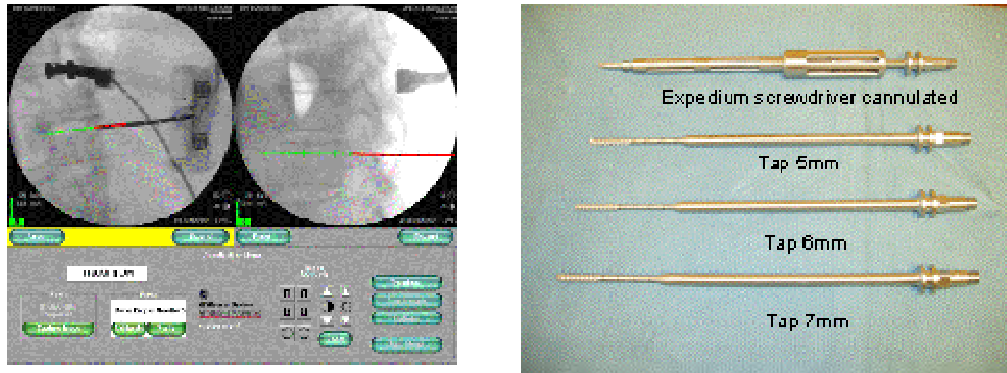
(Left) Virtual trajectory of the Nav trocar superimposed over the X-ray image. (Right) Cannulated MIS instruments co-designed by RVJ and J&J - Depuy Spine.
